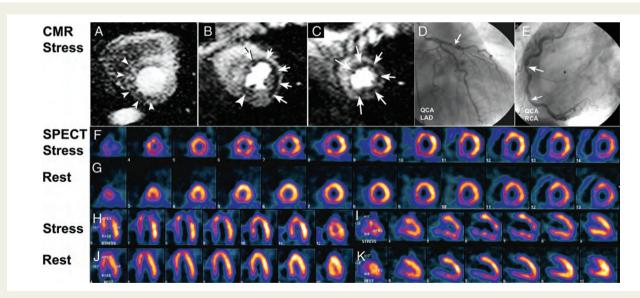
An example of a 67-year-old patient is shown with angina CCS II. The perfusion-cardiac magnetic resonance study during hyperaemia (at 0.075 mmol/kg Gd-DTPA-BMA) demonstrates a perfusion deficit in the subendocardium of the anterolateral wall (B and C; arrows). In the apical slice, almost the entire subendocardium is hypoperfused during hyperaemia (C, arrows). Another minor perfusion deficit is detected in the inferior wall of the basal and mid-ventricular slices (A and B, arrowheads). In the basal slice in (A), the inferior wall of the right ventricle also shows hypoperfusion in comparison with the right ventricular free wall. Single-photon emission computed tomography in this patient was positive with a predominant perfusion abnormality in the anteroseptal wall (F-K). Quantitative X-ray coronary angiography (QCA) demonstrated a severe stenosis in the left anterior descending coronary artery of 82% (LAD; D, arrow). The right coronary artery (RCA) shows two mild stenoses of 64 and 59% diameter reduction (E, arrows).
